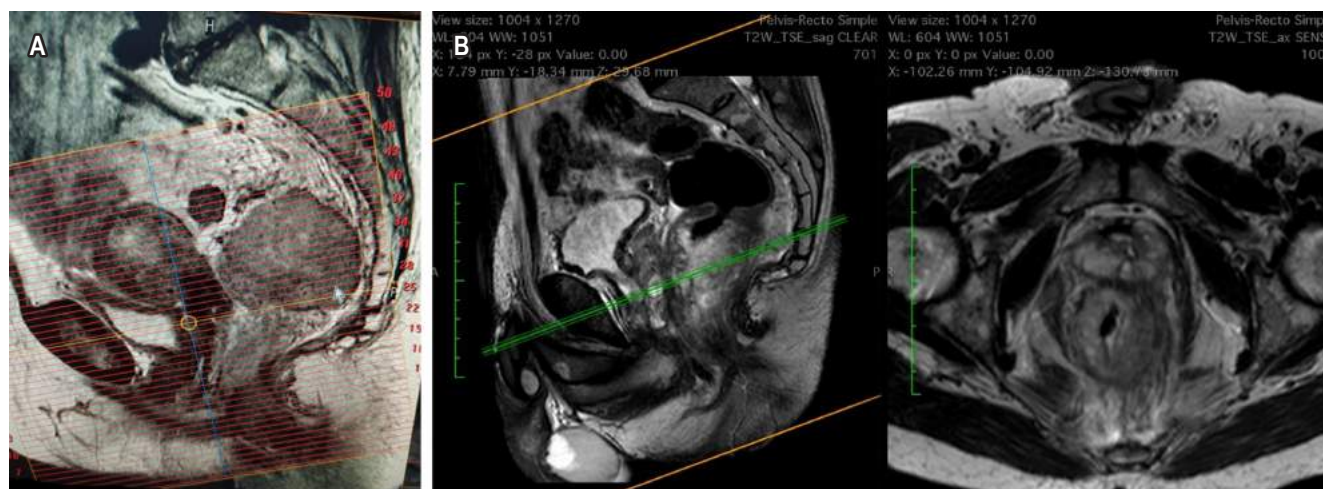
A. Simple rectum MRI. Planning of the cutting axis of the reconstruction packages for an actual staging of T. B. Verification that the axial cut corresponds to a perpendicular reconstruction to the tumor axis. Source of images: Authors' file.
